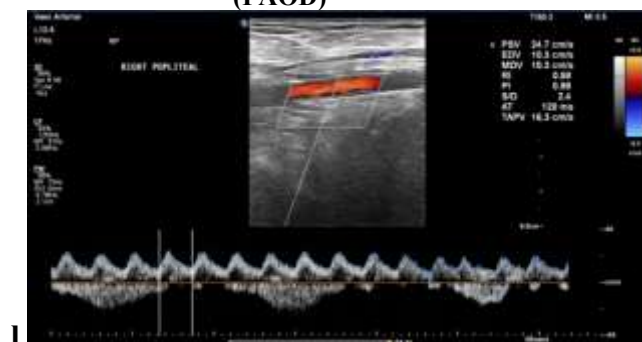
Image l. Color doppler and Spectral waveform of longitudinal section of right popliteal artery showing patchy color flow and low velocity monophasic waveforms- Partial thrombosis.
